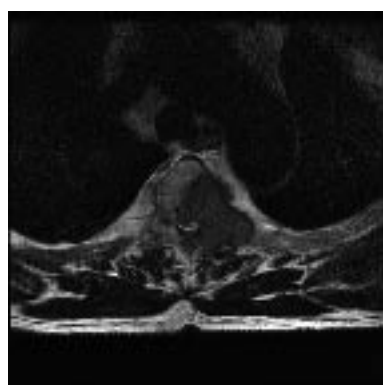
Thoracic spine MRI. The metastatic tumor of the third vertebra compressing the spinal cord (T2 weighted image).
